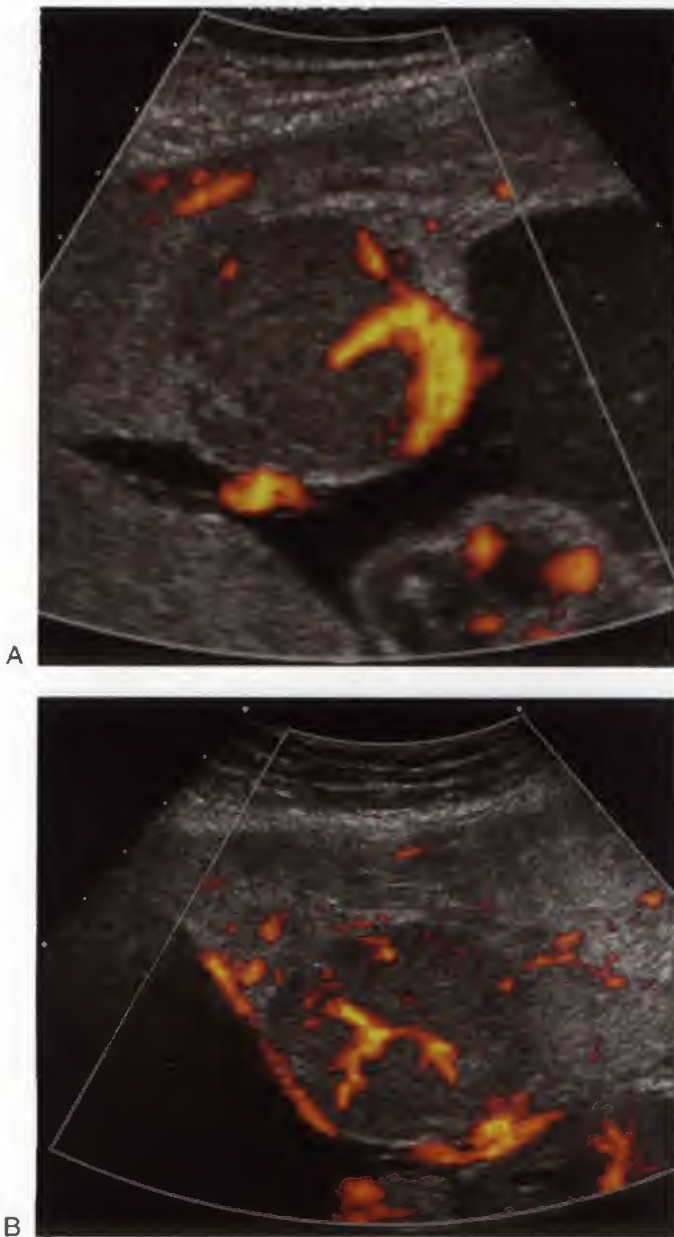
A. Sonogram from a 25-week-old gestation showing an incidental solid, relatively hypoechoic mass (arrow) at the fetal surface of the placenta. B. Blood flow is shown within this lesion on color Doppler ultrasound. This chorioangioma did not result in fetal compromise and was confirmed postnatally.
